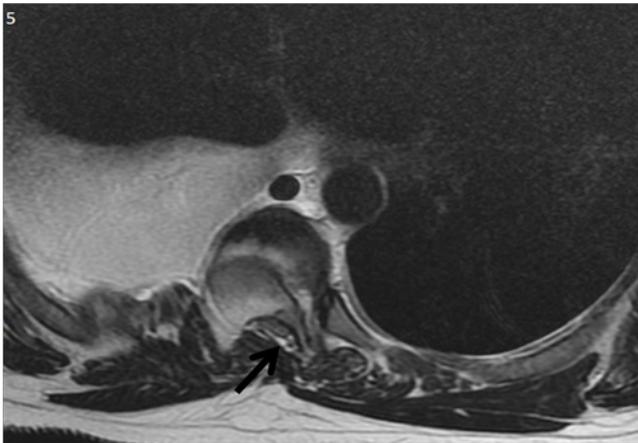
Magnetic Resonance Imaging, axial acquisition enhanced in T2. Spinal canal stenosis with spinal cord compression (black arrow).
